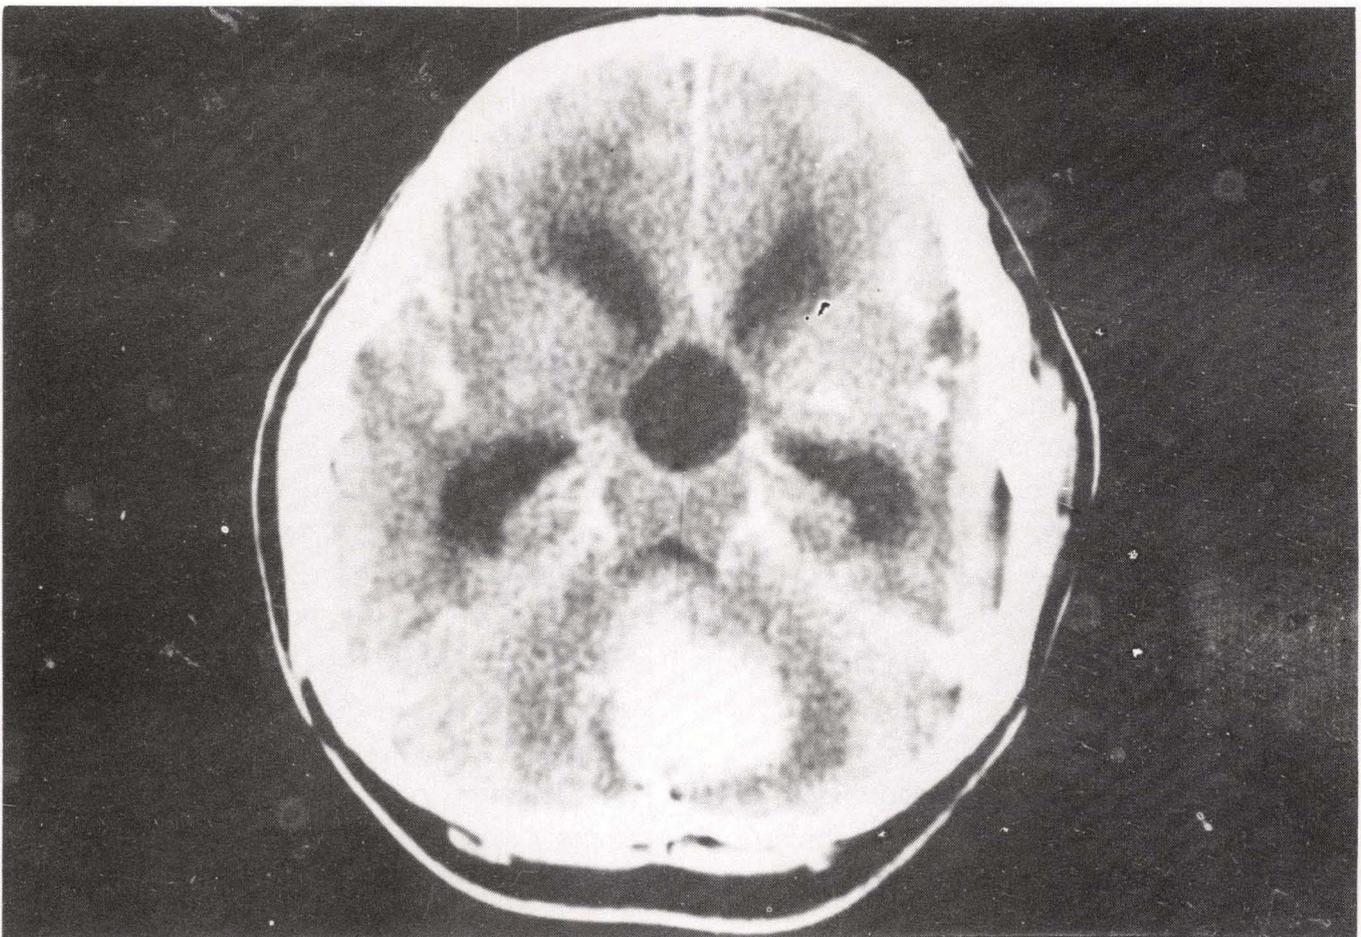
A brain CT scan showed a homogeneously enhanced round mass lesion in the midline of the posterior fossa with marked hydrocephalus.
